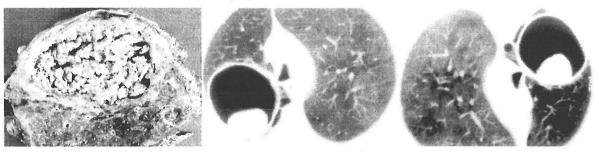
Gross pathology and CT appearance of an aspergilloma. Note that the mycetoma is mobile within the lung cavity.
